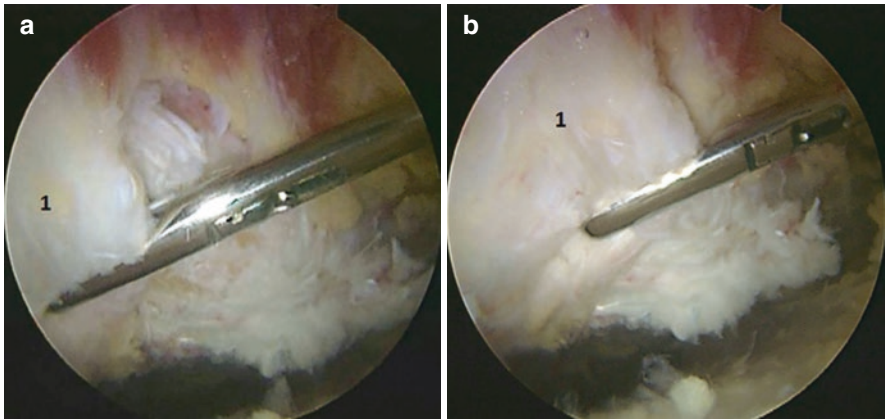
(a) Once the tendon edge is clearly demarcated, the degenerated tendon is debrided, and the free edge of the tendon (*1*) is assessed for mobility. (b) The edge of the gluteus medius (*1*) is being held by a suture grasper and pulled distally to its normal insertion site at the footprint of the lateral facet. If the tendon is retracted and cannot be mobilized, then conversion to an open procedure may be necessary, although this can usually be determined preoperatively based upon the MRI findings. Reuse with permission from Springer [27]
